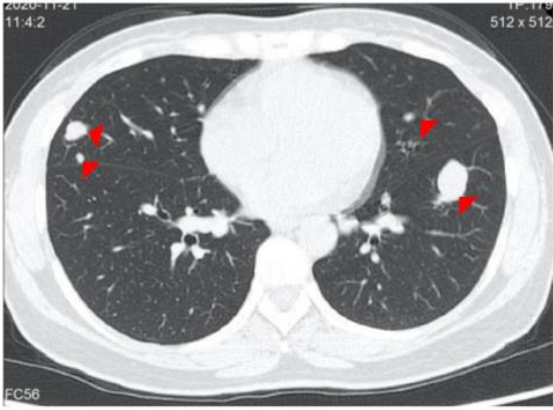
Chest CT images after admission
